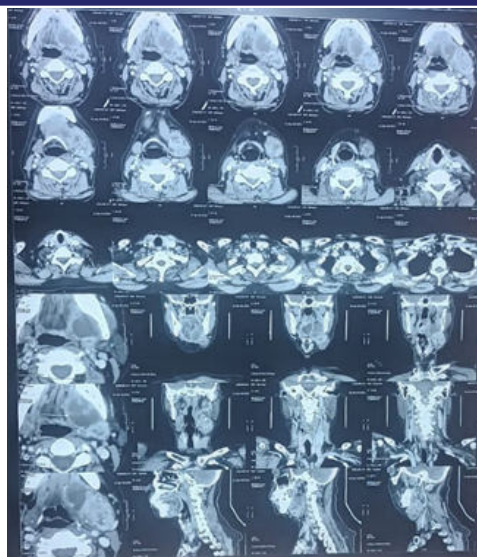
CT scan - left enlarged submandibular gland with multinodular cystic lesion
